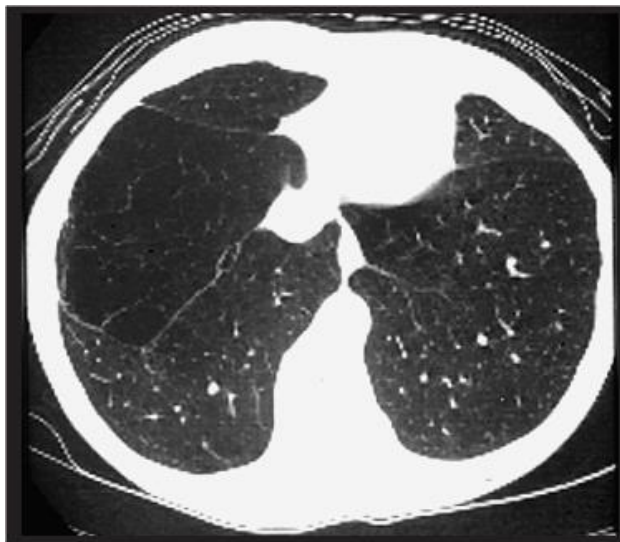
Axial HRCT Thorax with panlobular Emphysema
